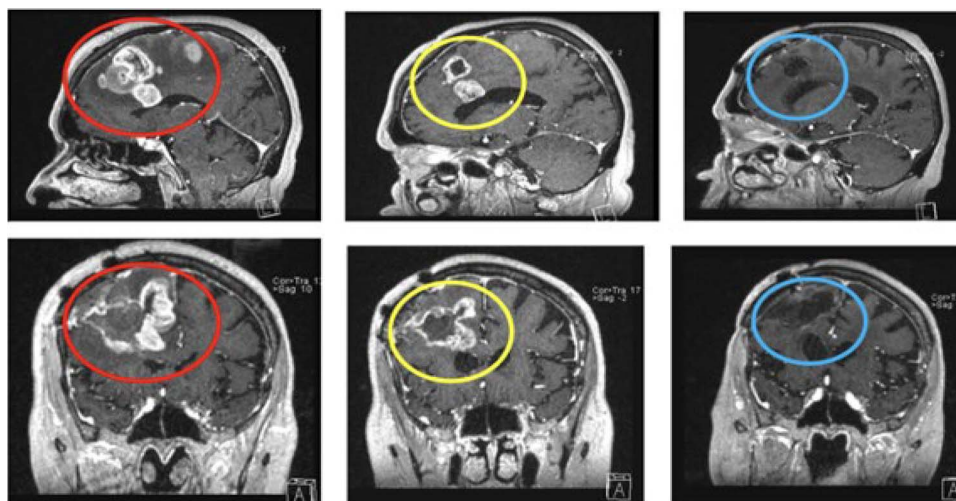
Serial magnetic resonance images of the brain for case 1 (T1 postcontrast images). *Left:* Postoperative multifocal mass in the right frontotemporal area (red circle) accompanied by surrounding edema. *Middle:* At 1 month follow-up after concurrent radiochemotherapy, the mass had partially reduced in size, while the edema persisted in the same area (yellow circle). During this period, treatment with imatinib and bevacizumab was initiated. *Right:* By the 28th month after the administration of bevacizumab and imatinib, there was no contrast-enhancing lesion observed in the area (green circle), consistent with complete radiological response. The patient was progression-free at 39+ months.
